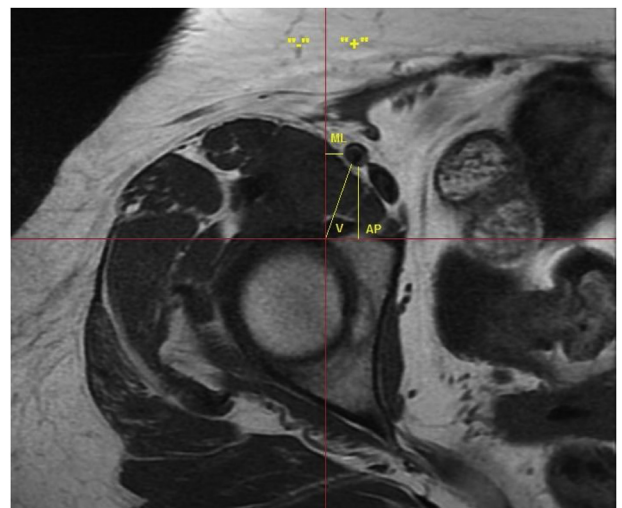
Axial MRI of the hip with lines drawn to demonstrate methodologies for the measurement of the AP, ML, and V distances from the anterior acetabular wall to the femoral artery.
